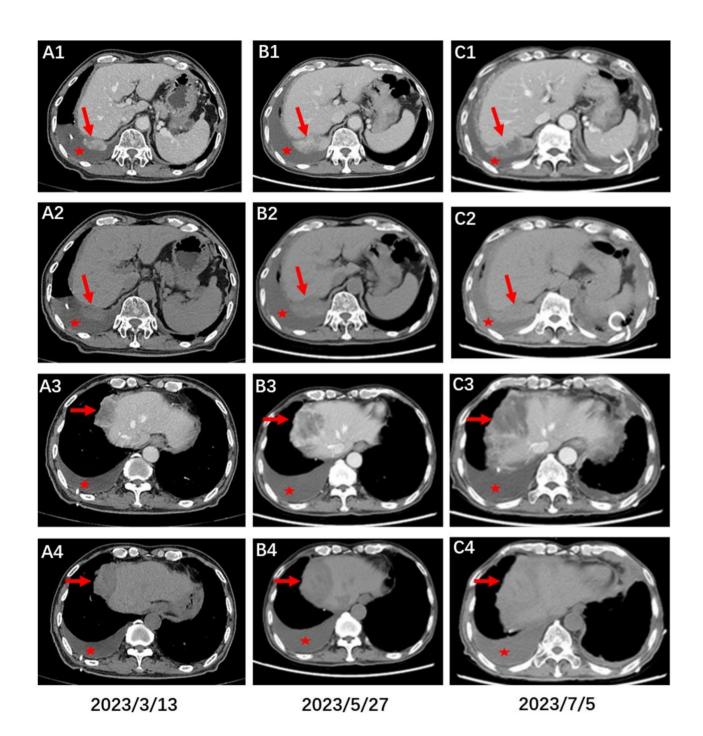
Changes in right diaphragmatic tumors during treatment on CT scans. A1-4 exhibited two mass lesions (A1, A2, A3, and A4; denoted by red arrows) on the right diaphragmatic surface in both non-contrast CT scans (A2, A4) and contrast-enhanced CT scans (A1, A3). These were accompanied by right pleural effusion (marked by red asterisks). Following two cycles of treatment, B1-4 revealed enlargement of the two mass lesions (red arrow) on the right diaphragmatic surface and an increase in right pleural effusion (A1, A2, A3, and A4; indicated by red arrows). One month later, C1-4 demonstrated further enlargement of the two tumors on the right diaphragmatic surface (red arrows) and a further increase in right pleural effusion (red asterisks)
